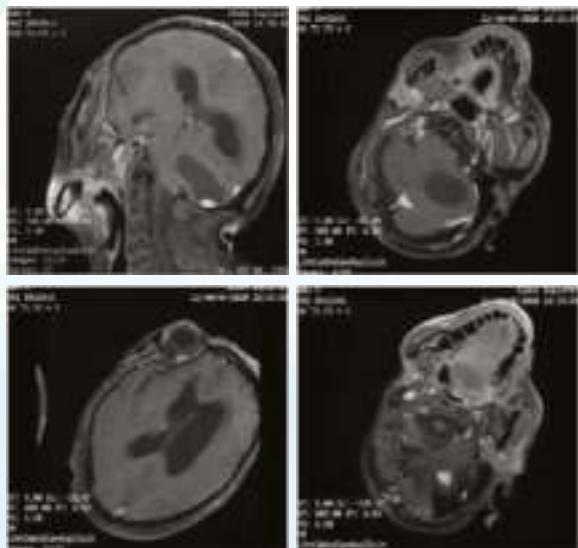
pre operative MRI showing cystic lesion with mural nodule
